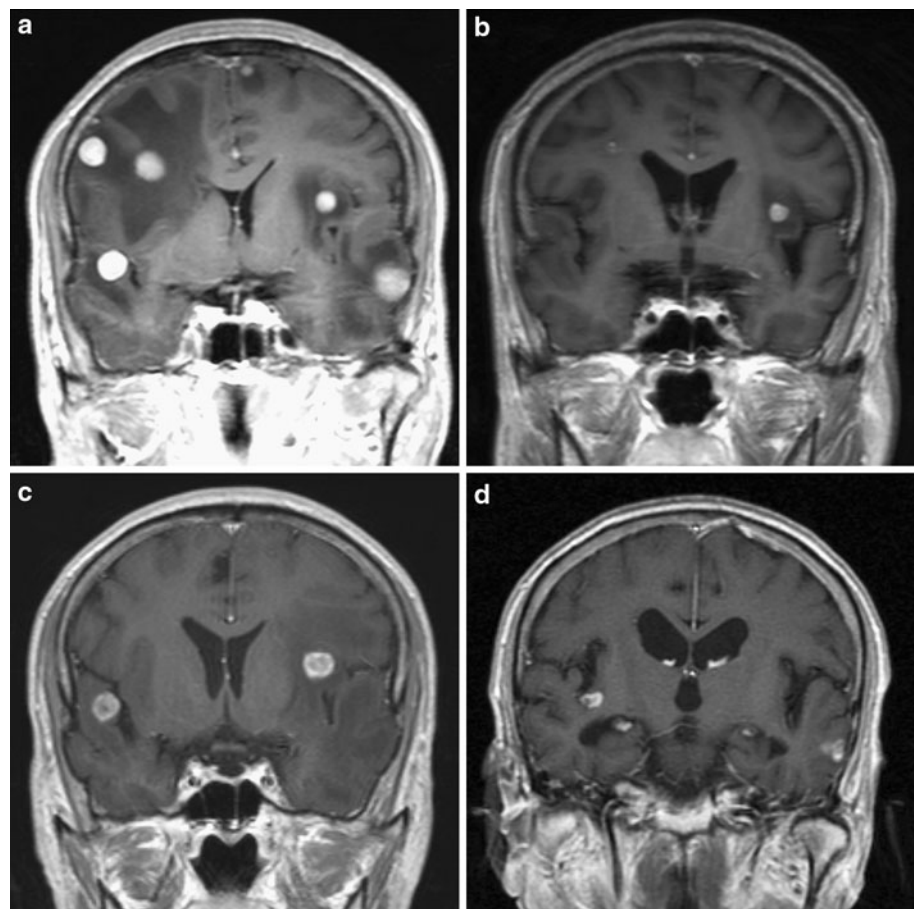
Whole-brain radiotherapy (WBRT) was performed on a 61-year-old male patient (patient #14 in Table 1) with multiple metastases. a A T1-weighted gadolinium-enhanced coronal image shows multiple lesions prior to WBRT. b Three months after WBRT, there was decrease in the enhanced lesions. c Six months after WBRT, MRI showed an increased size and number on the right temporal and left insular areas, prior to GKR. d The post-GKR 12-month follow-up MRI showed a decreased size and number of tumors
